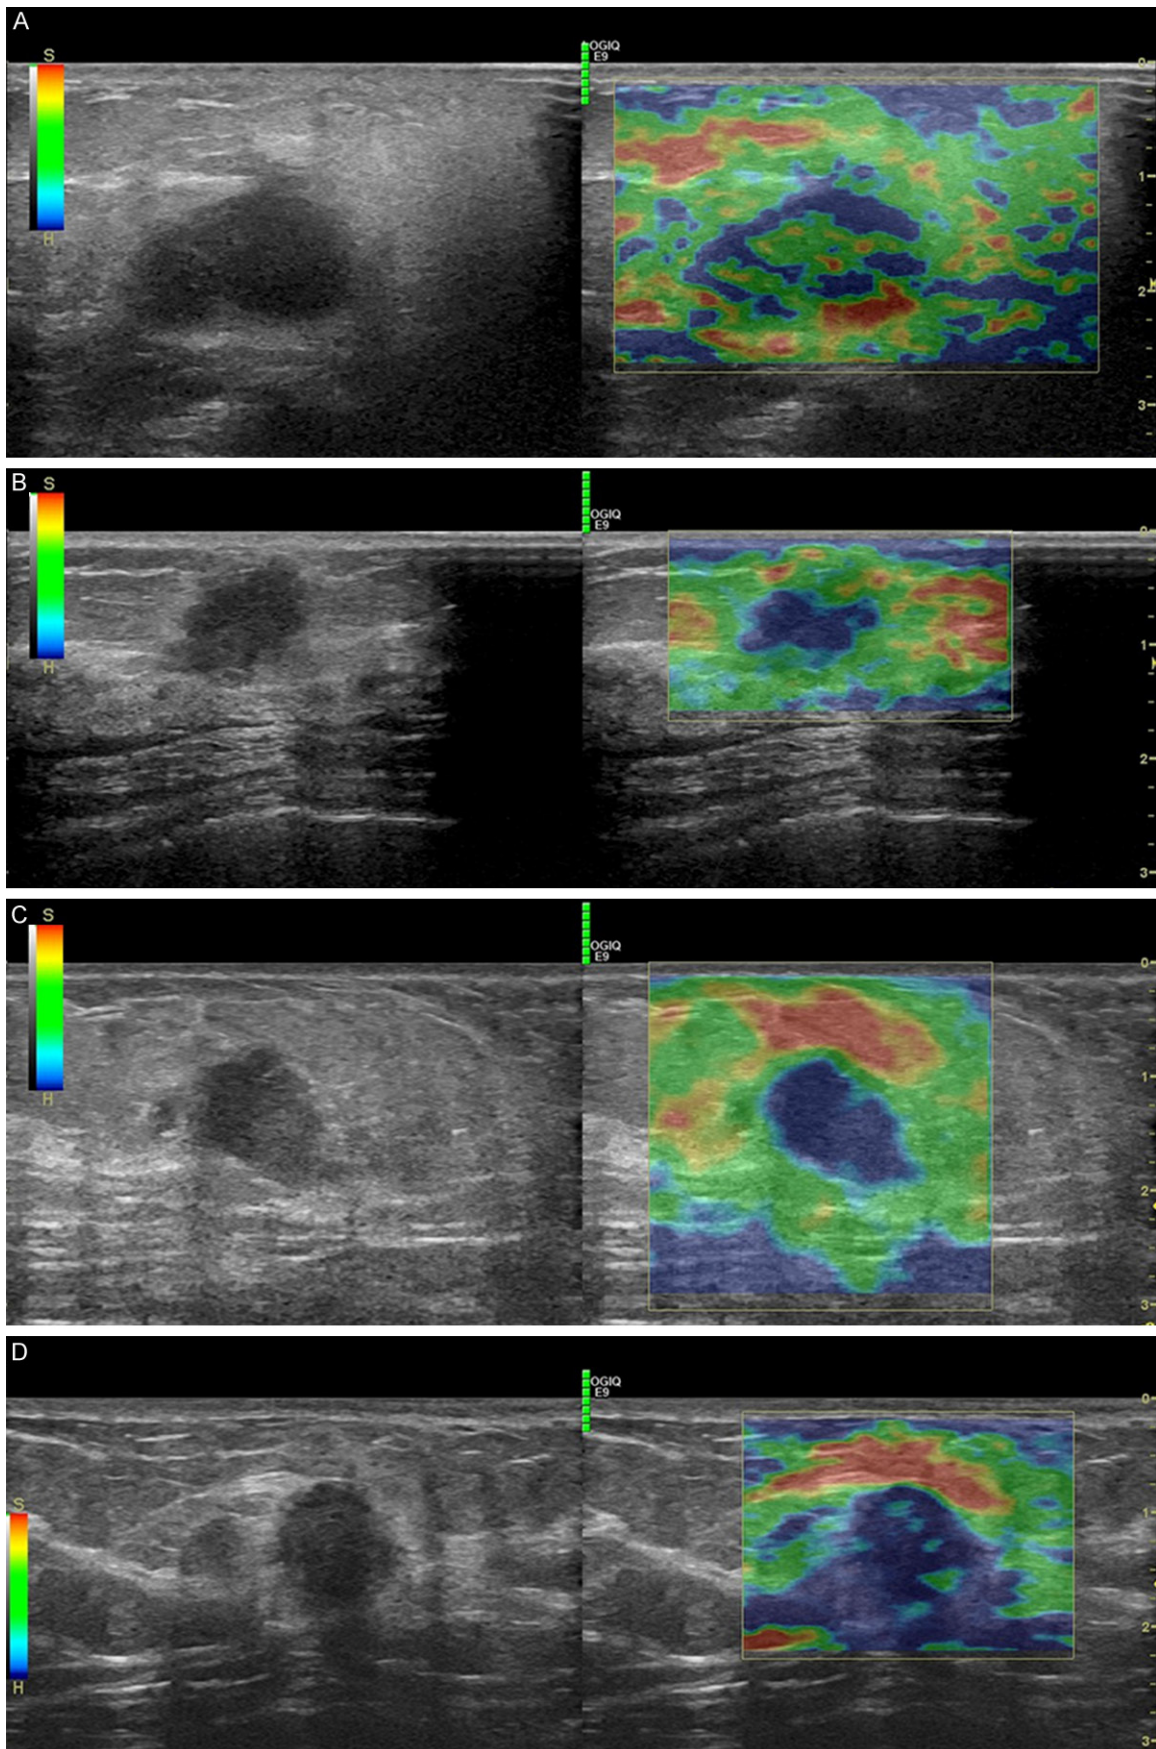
A: Ultrasound elastography of a 17.6-mm-sized, grade 3 primary breast IDC in a 40-year-old woman without axillary nodal metastasis showed the hypoechoic lesions with a mosaic pattern of green and blue. The elasticity score was 2. B: Ultrasound elastography of an 11.1-mm-sized, grade 2 primary breast IDC in a 61-year-old woman without axillary nodal metastasis showed the green periphery and blue center. The elasticity score was 3. C: Ultrasound elastography of a 12.5-mm-sized, grade 2 primary breast IDC in a 41-year-old woman without axillary nodal metastasis showed the entire lesion was blue (non-including surrounding area). The elasticity score was 4. D: Ultrasound elastography of a 12.5-mm-sized, grade 2 primary breast IDC in a 41-year-old woman with axillary nodal metastasis showed both the entire hypoechoic lesion and its surrounding area were blue. The elasticity score was 5.
